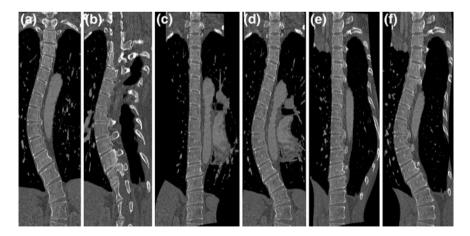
A coronal cross-section of a 3D CT image of a scoliotic spine, obtained by a orthogonal MPR, b oblique MPR, c orthogonal CPR (with anatomical deformations), d orthogonal CPR (without anatomical deformations), e oblique CPR (with anatomical deformations) and f oblique CPR (without anatomical deformations)
